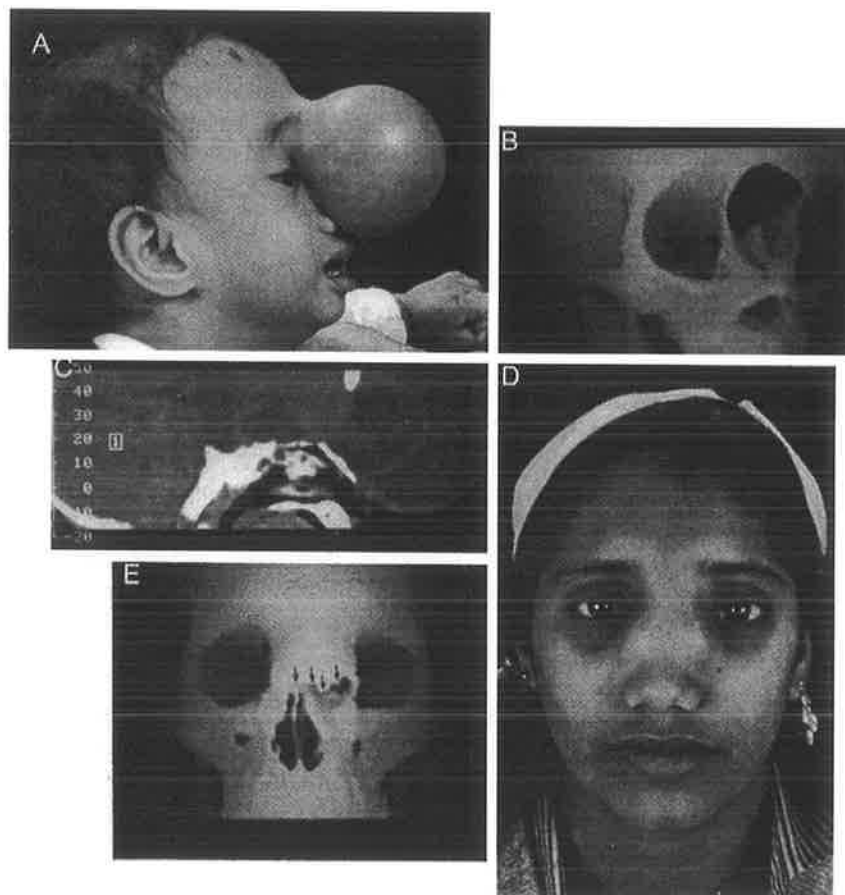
A—C, a large nasofrontal type of frontoethmoidal meningoencephalocele. Three-dimensional CT reconstruction shows the facial defect with the nasal bones inferiorly. The sagittal section demonstrates the depressed cribriform plate at the base of the bony defect. D and E, a nasoethmoidal type of frontoethmoidal meningoencephalocele. The distorted nasal bones can be seen in the three-dimensional CT reconstruction. (Continued.)
